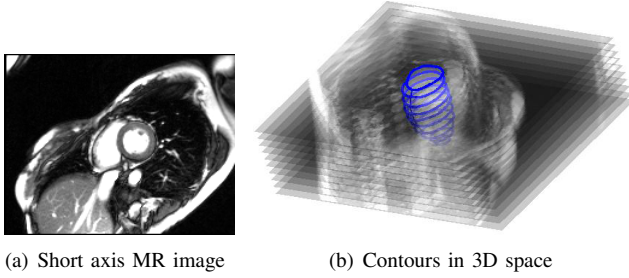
MR images and contours
